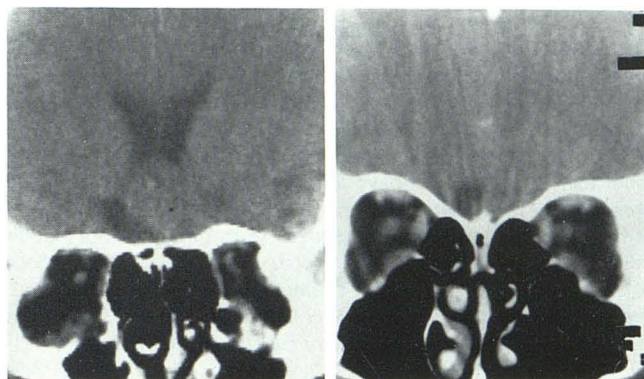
Contrast-enhanced CT in two cases with posttraumatic subfrontal atrophy around right olfactory bulb and encephalomalacia of adjacent frontal lobe.
